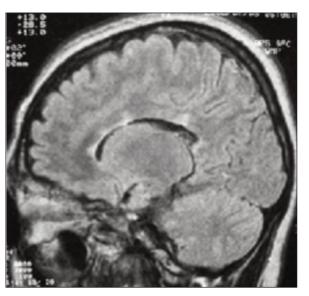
Sagittal FLAIR image to the left of the midline shows multiple periventricular plaques affecting the corpus callosum.
